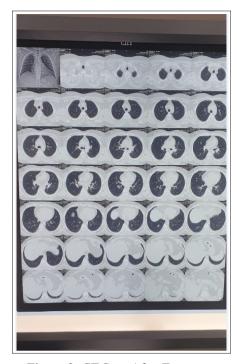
CT Scan After Treatment
